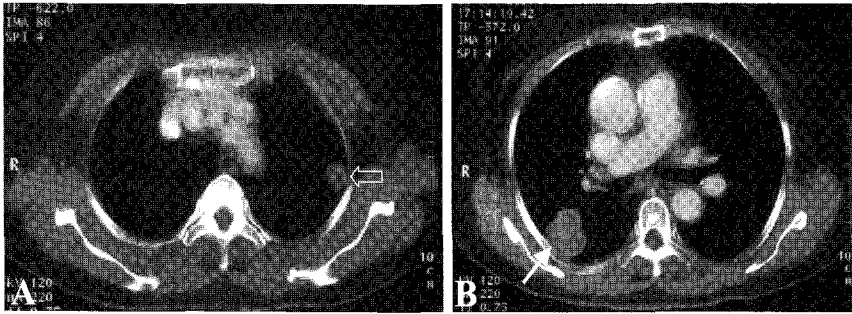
A 67-year-old woman presented with two well-defined spherical nodules in the left-upper and right-mid lung fields on chest X-ray, which corresponded to hematogenous lung metastasis. The patient had a history of anterior resection and hepatic wedge resection due to a moderately differentiated adenocarcinoma of the rectum with liver metastasis several weeks previously. Contrast-enhanced computed tomography of the chest shows the masses of soft tissue densities with lobulated margins in both (A) the left-upper and (B) right-mid lung zones. Their size were 2 cm-diameter in the left (open arrow) and 3.5 cm-diameter in the right (arrow). Mass densities were not seen in the hilar region corresponding to the increased hilar activities on Ga-67 SPECT images.
